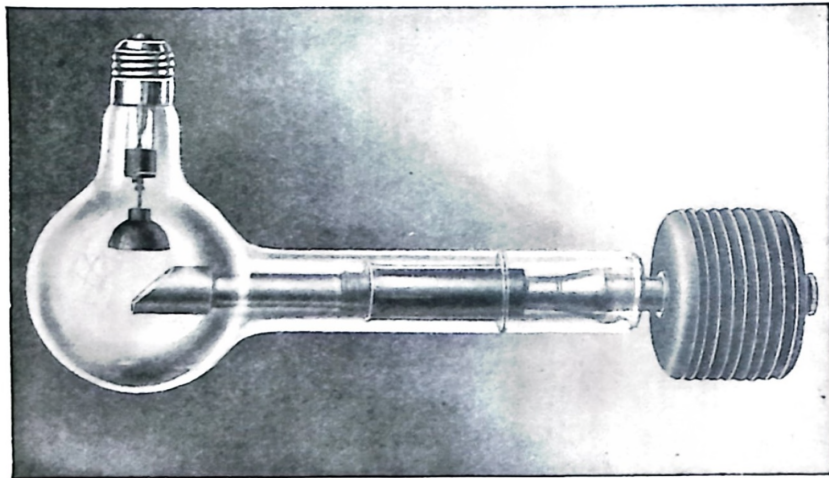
Radiator Dental Type Coolidge X-Ray Tube
